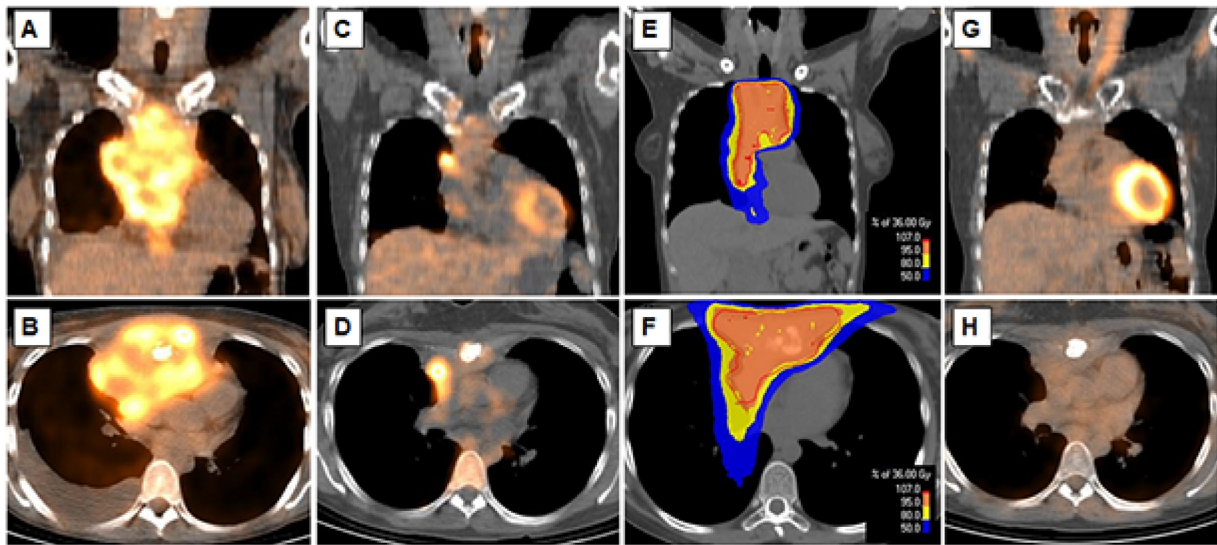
Consolidative Radiotherapy for an advanced stage HL with PET-positive residuals after chemotherapy. (A, B) Prechemotherapy PET-CT of a 40 year-old lady diagnosed with a stage IIB nodular sclerosis cHL, with a bulky mediastinal mass. (A) coronal view and (B) axial view. The patient was enrolled in a prospective phase III trial and received 6 cycles of intensified ABVD. (C, D) PET-CT after 6 cycles of intensified ABVD reveals a PMR response with 3 FDG-avid foci in the original mediastinal mass (3-times > liver uptake on central PET review: Deauville Score 5). (C) coronal view; (D) axial view. (E, F) Dose distribution of consolidation RT to the residual metabolically active disease site within the morphologic remnant of the original bulky site, as per study protocol. RT dose = 36 Gy. (E) Coronal color-wash dose distribution of the 6 MV photon VMAT plan (F) Axial color-wash dose distribution. The patient achieved CMR on the repeat PET 3 months after RT (G, H) and is in durable remission 5 year after the end of treatment.
